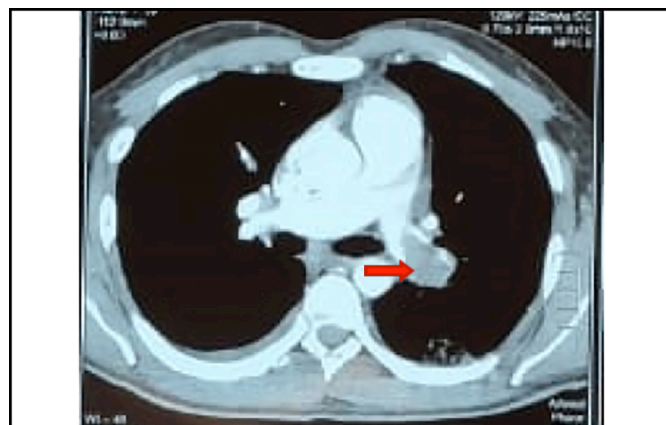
CT pulmonary angiography. A large hypodense intraluminal filling defect can be seen in the left main pulmonary artery ($3.4 \times 2.1 \text{ cm}$) extending predominantly into the left inter-lobar artery as indicated (arrow).
